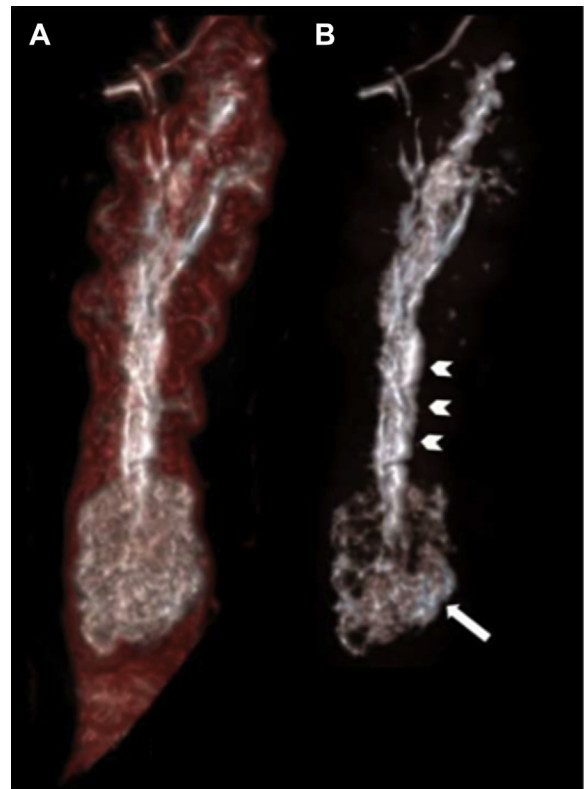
CT VR reconstruction of polypoid lesion (A, with colonic wall and B, without colonic wall) shows a large “head” (arrow) and a long stalk (arrowhead) like a clapper-bell.
